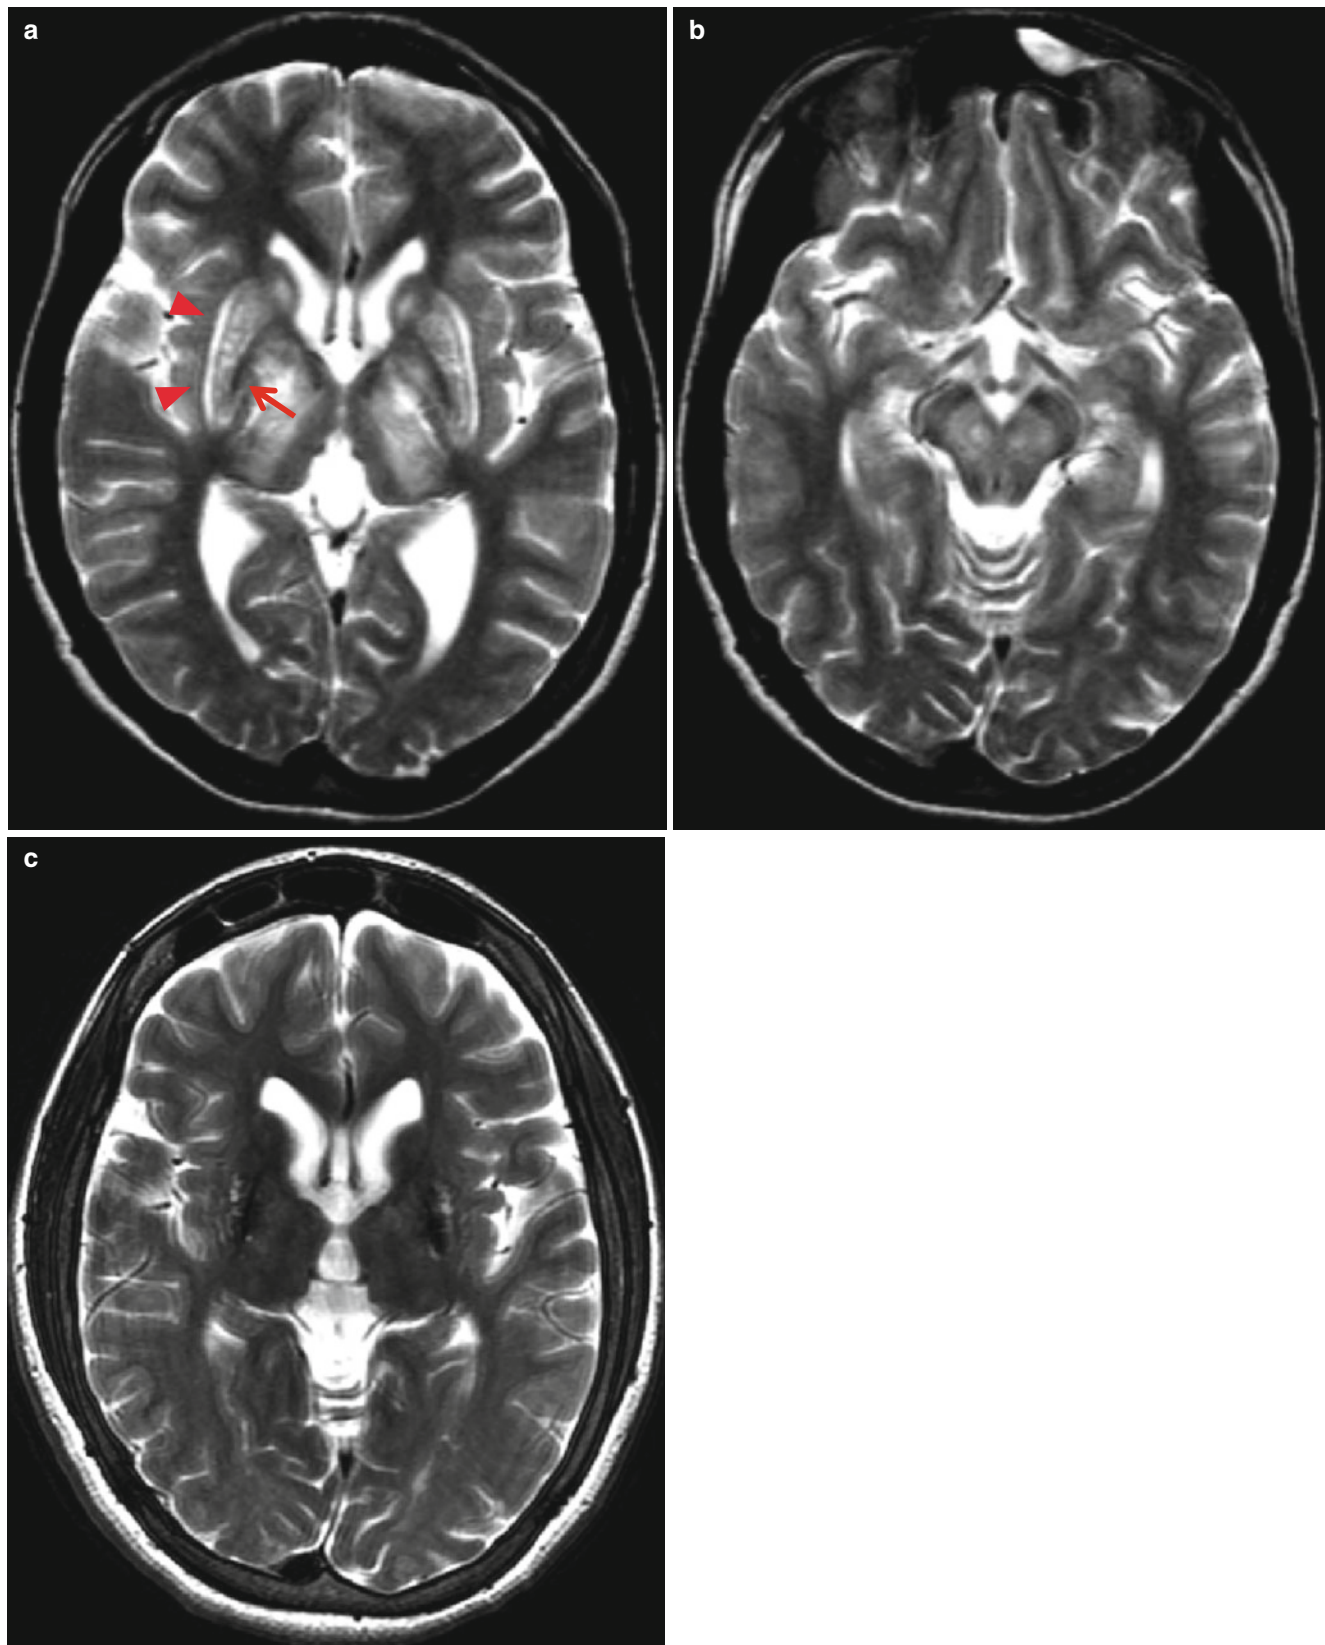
Wilson's disease in a 14-year-old girl with seizures and dysarthria. (a, b) T2-weighted images show high-signal intensities involving the basal ganglia, thalamus, and the midbrain. Exaggerated linear high signals are seen in the outer margin of the putamen (*arrowheads*)
